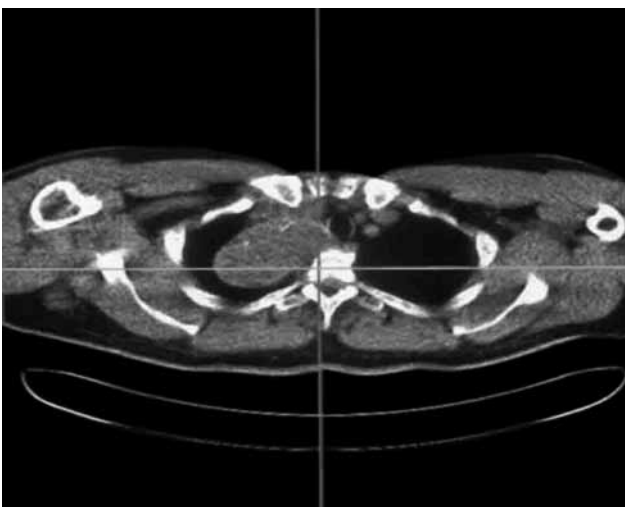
In the PET-CT of the patient the right posterior mediastinum mass is seen.
